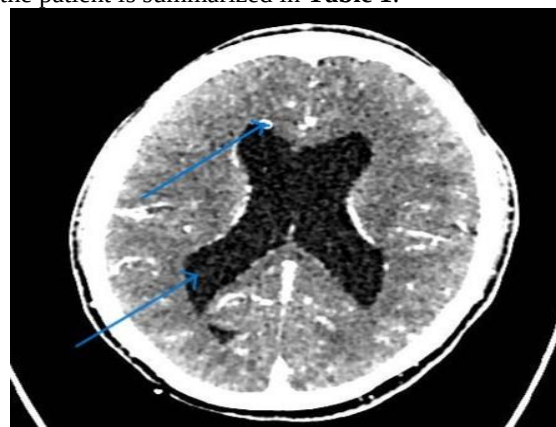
CT brain with contrast: The previously observed right periventricular space-occupying lesion is no longer visible.
